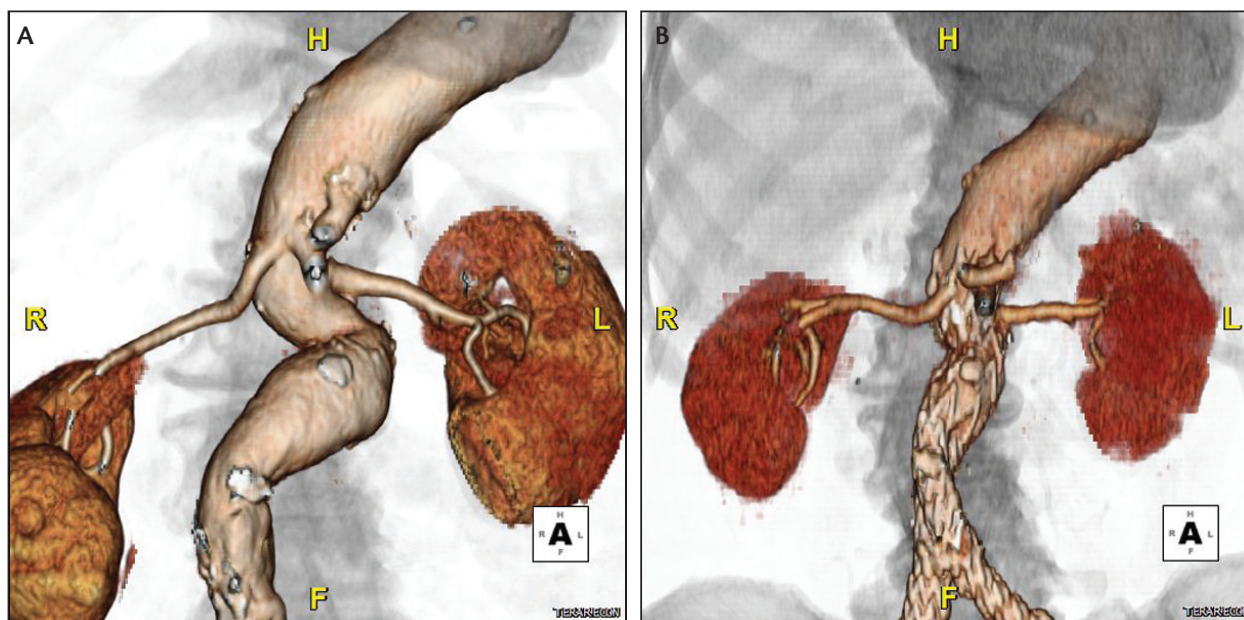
Preoperative CT angiogram of an AAA with a double severe angulation of the short proximal aortic neck (A); postoperative CT angiogram showing the precise deployment and the conformability of the INCRRAFT® Stent Graft System to the tortuous anatomy (B).
